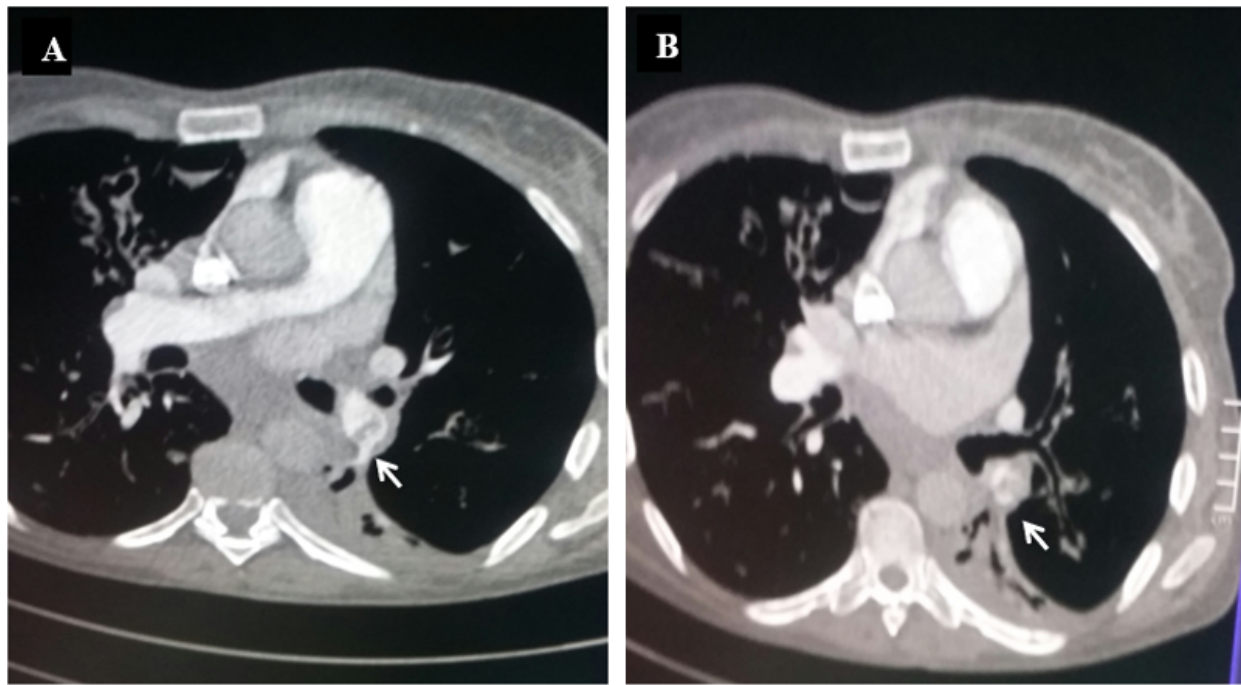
Initial thoracic CT angiography, performed in the pulmonary artery phase (mediastinal window), axial slice: hypodense gap in the left lower lobe artery (arrow) suggesting pulmonary embolism.
